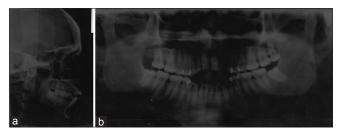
(a and b) Pretreatment lateral cephalogram and orthopantomogram
